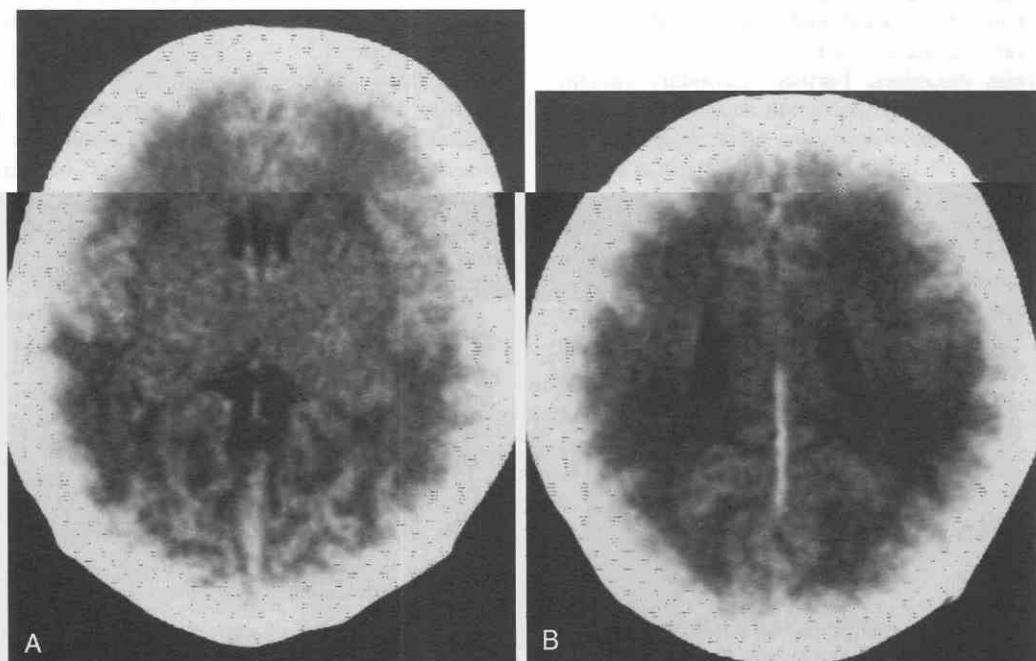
CT scans of myelin in a normal neonate. The immature myelin with its high water content imparts a generalized lucency to the central white matter. Note especially the discrete border with overlying cortical tissue. The internal capsule, however, having more mature myelination, is not visualized separately.
